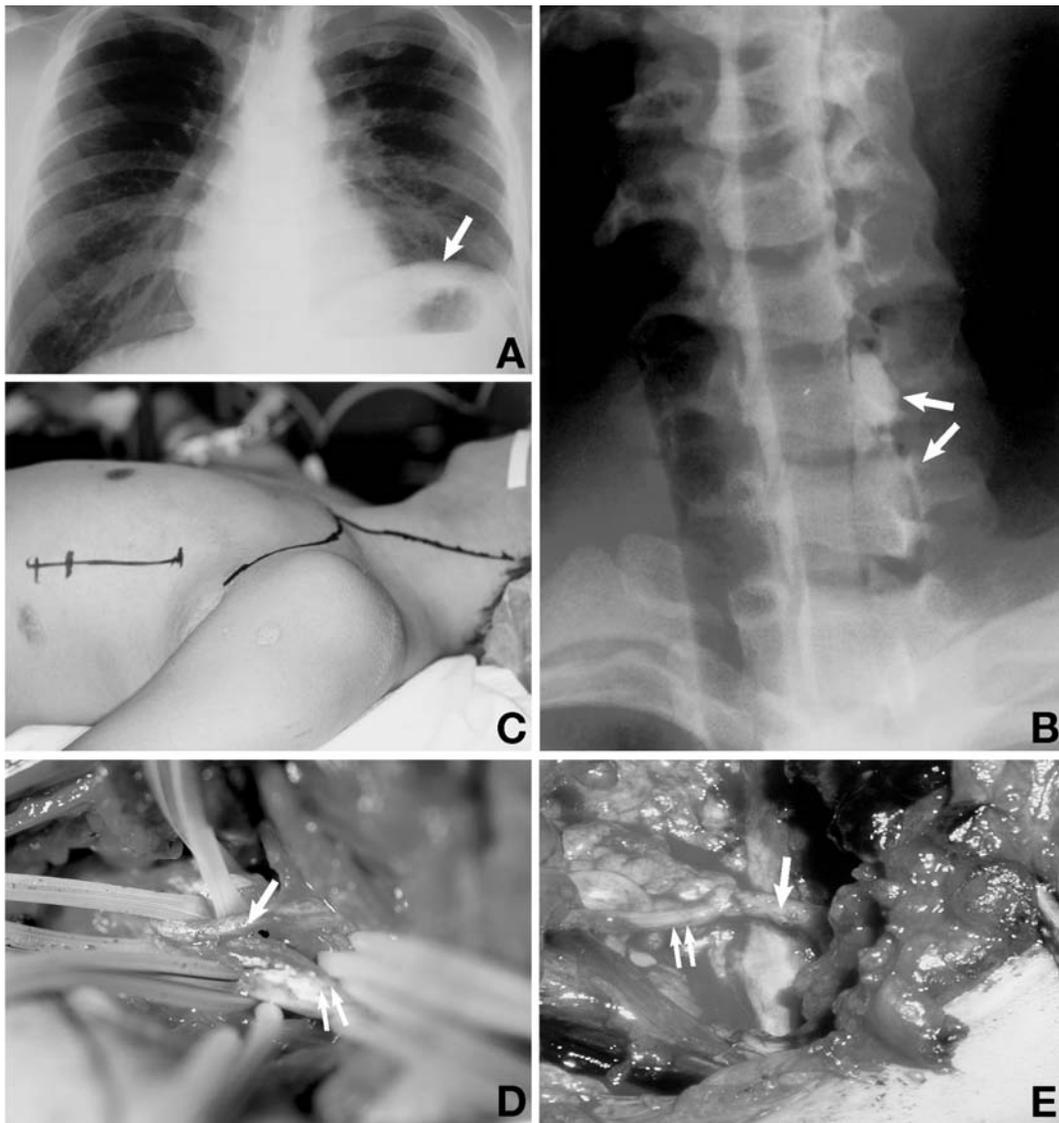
Case 4. Intercostal-musculocutaneous neurotization was performed for C5-T1 paralysis. (A) Chest radiograph showing elevation of the left diaphragm (arrow), indicating the left phrenic nerve paresis. (B) Myelogram showing pseudomeningocele (arrows) at the C-8 and T-1 levels. (C) Intraoperative photograph showing skin incisions for neurotization. (D) Musculocutaneous nerve (arrow) was exposed. double arrow: Median nerve. (E) Musculocutaneous nerve (arrow) was coapted to a sural nerve (double arrow).
